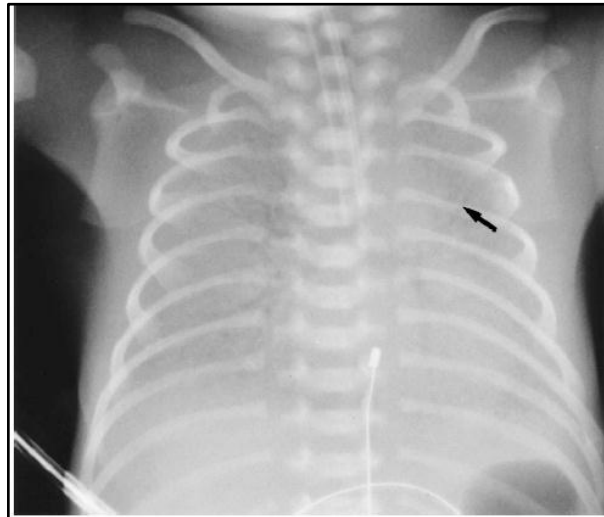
Severe hyaline membrane disease resulted in a “white” lung on an x-ray.<sup>9</sup>
